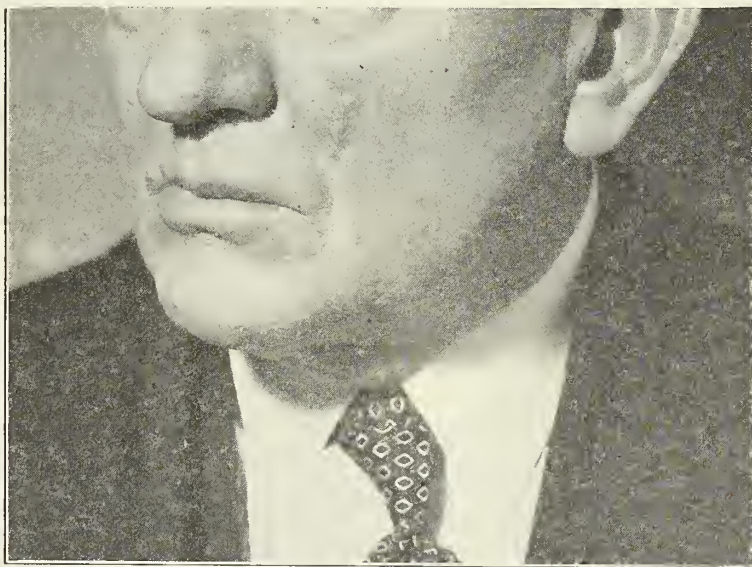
Basal cell epithelioma after treatment with electrocoagulation followed by treatment with Roentgen rays to the site of the tumor
